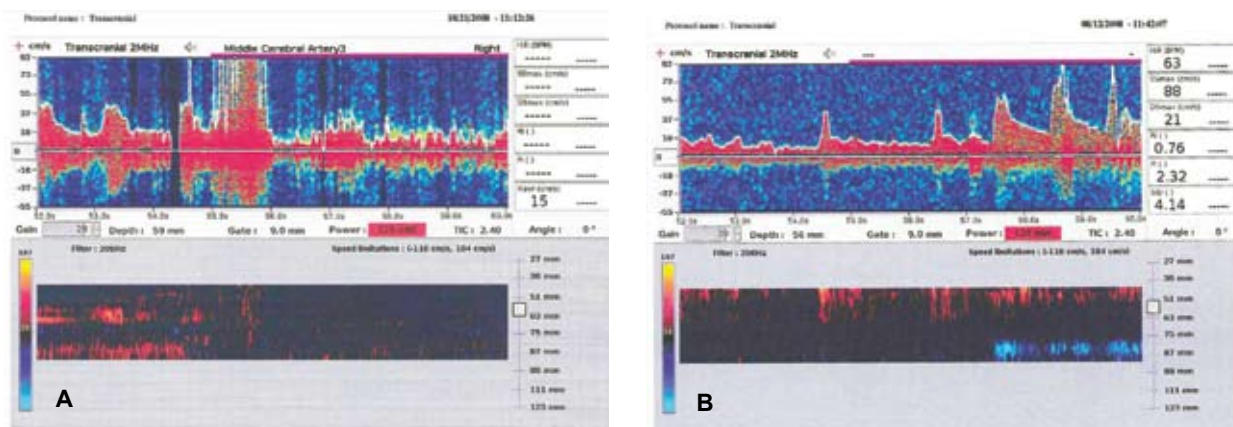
Transcranial Doppler middle cerebral artery blood flow velocity (MCAV) during off-pump coronary artery bypass grafting (OPCABG): (A) temporary cessation of blood flow during lifting and manipulation of the heart; (B) restoration of blood flow after stabilization of the heart.
